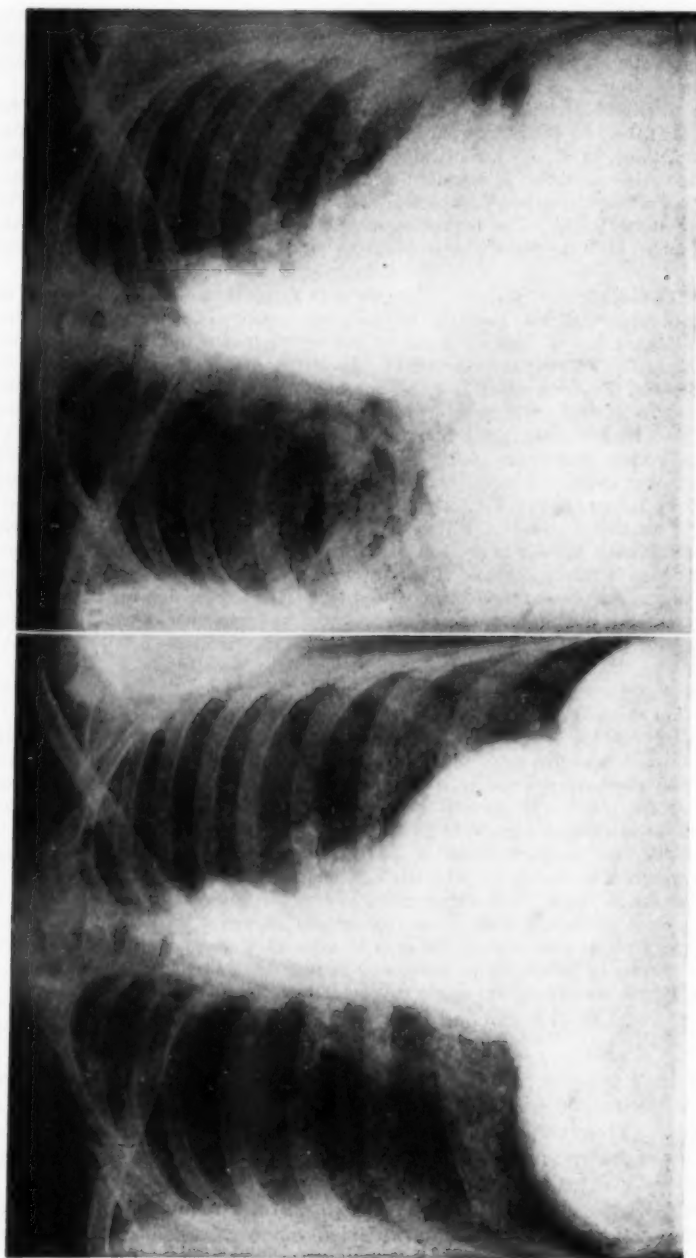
A. Standard six foot PA chest x-ray on the twenty-third hospital day, showing further diminution in the nodular infiltration. B. Standard chest x-ray on the fourteenth hospital day, showing consolidation in portions of both lower lobes.
